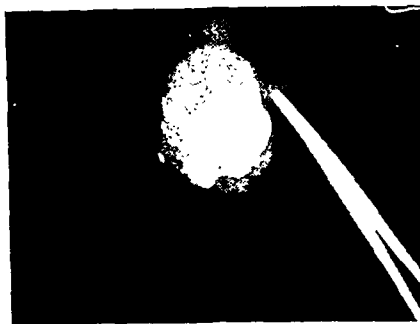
Roentgenogram of tumor (Case 2) showing calcification.
